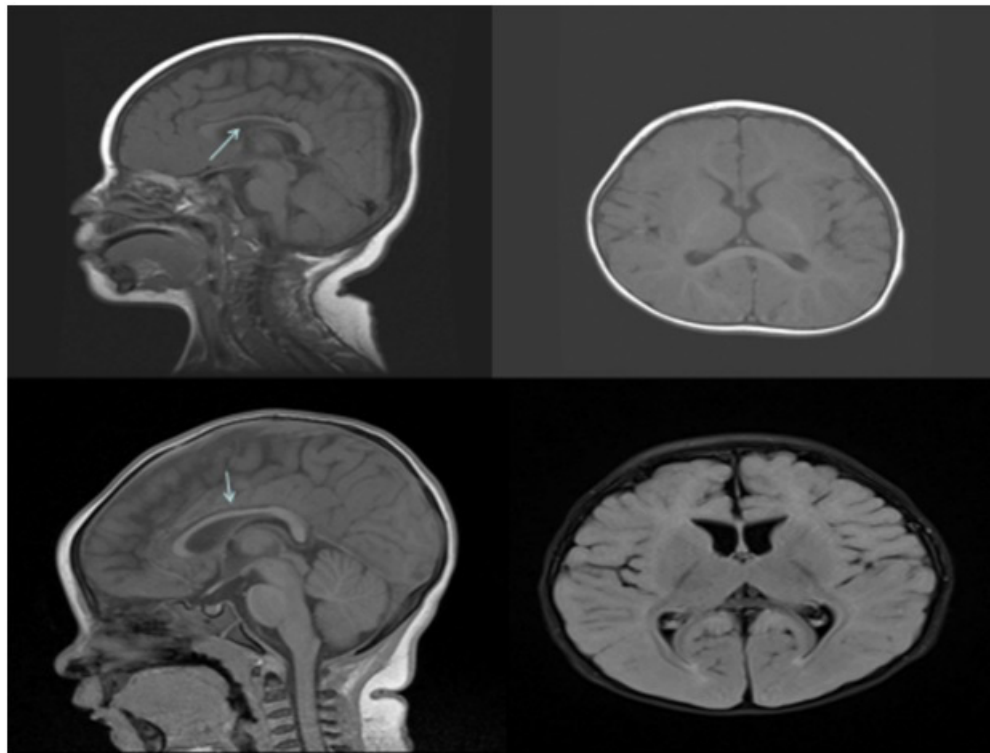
Her MRI show a thin corpus callosum (arrows).
